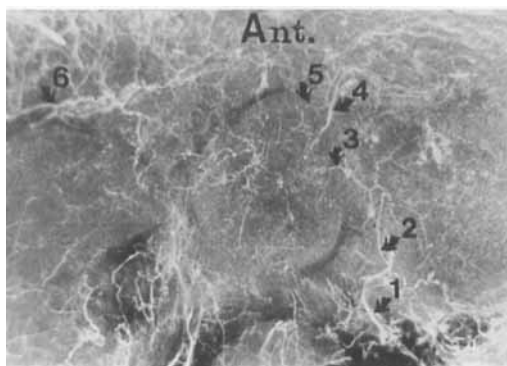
Horizontal section through the base of the odontoid process. Radiograph of Spalteholtz preparation. (cf. Figure 4 c, no. 3; slice thickness 12 mm). The odontoid process is in the centre of the picture. Seen from above and posteriorly.
